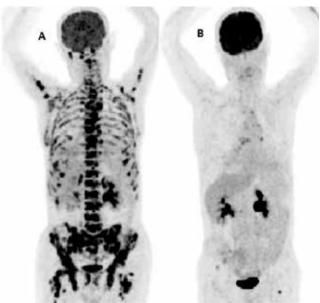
(A) Initial positron emission tomography–computed tomography (PET–CT) scan showed gastric cancer in the pyloric end, multiple liver, bilateral adrenal and widespread bone metastasis in the maximum intensity projection. (B) After 12 cycles of mFOLFOX-based chemotherapy, the follow-up PET-CT scan showed the nearly complete remission of gastric cancer and metastatic areas.
